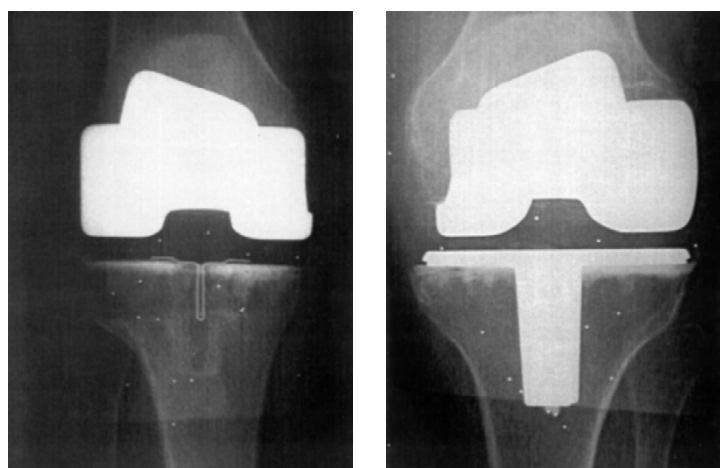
Standard anterior postoperative radiographs of the a) all-polyethylene, horizontally cemented (APHC), and b) metal-backed, horizontally cemented (MBHC) tibial components.
